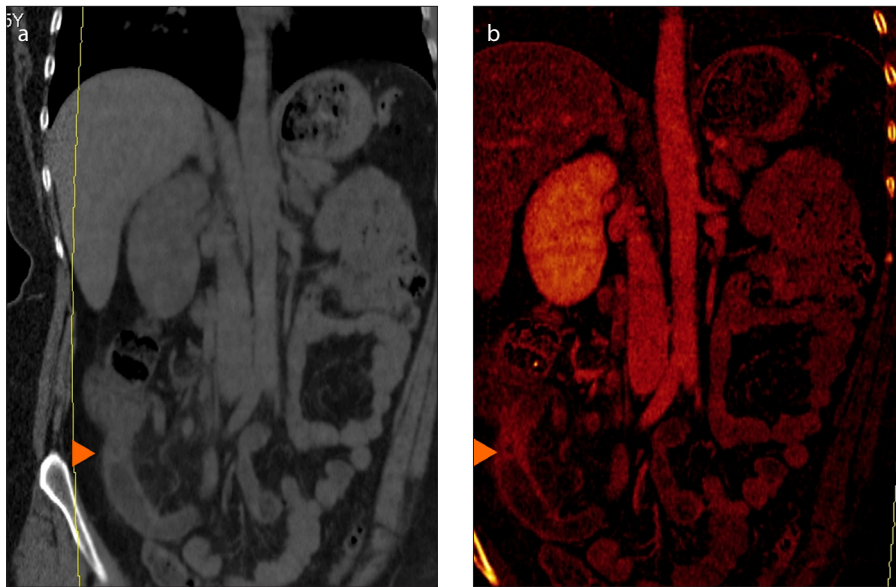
a, b. In dual-energy computed tomography (DECT), virtual noncontrast (VNC) images are easily reconstructed without extra scans. VNC image (a) reveals a distended appendix (arrowhead). Iodine map image (b) demonstrates increased iodine uptake (arrowhead) in the appendiceal wall due to inflammation. Note the slight hyperattenuation of the inflamed appendiceal wall in the VNC image.
